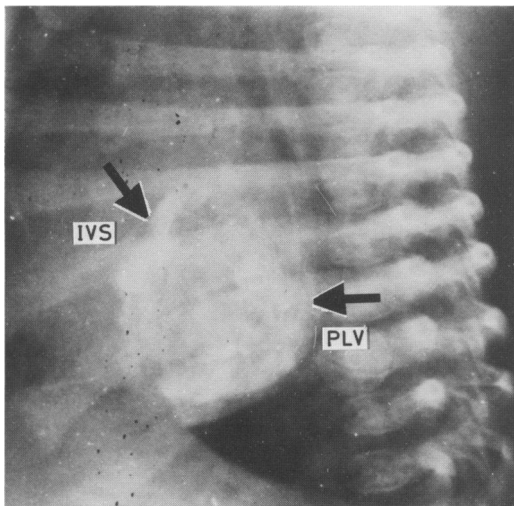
Lateral radiograph of chest taken at age 6 weeks showing widespread calcification of the left ventricle (arrows). IVS, interventricular septum; PLV: posterior left ventricular wall.
